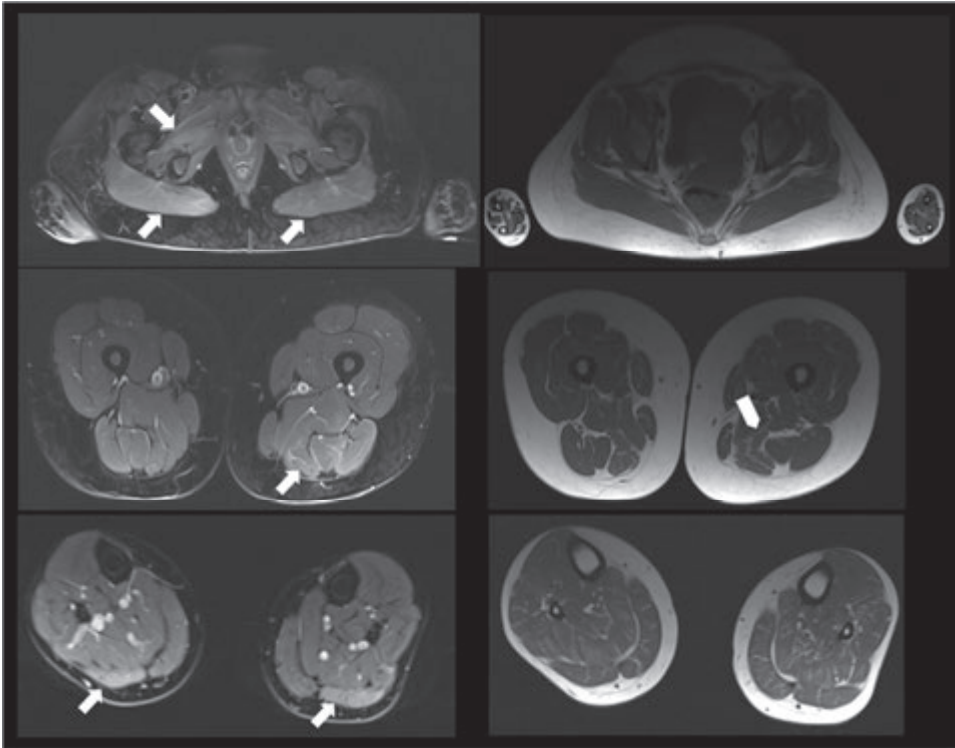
Axial images of lower limbs by T2 Dixon muscle MRI of the described patient in case vignette 1.
